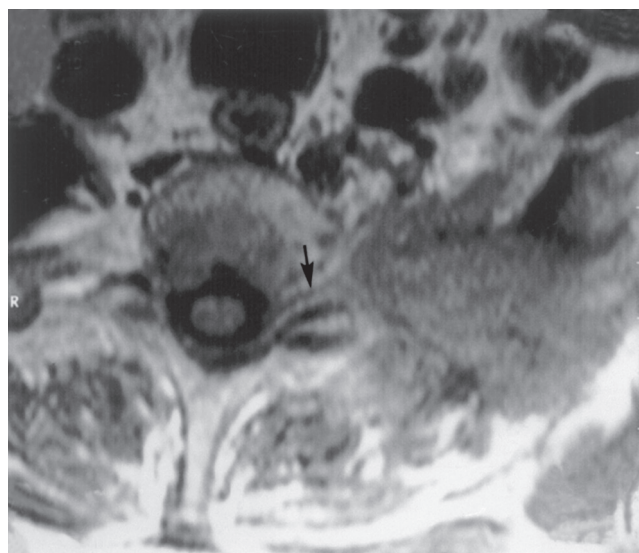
■ Magnetic resonance image of a right superior sulcus bronchial carcinoma extending into the intervertebral foramen (arrow) without intraspinal extension.
